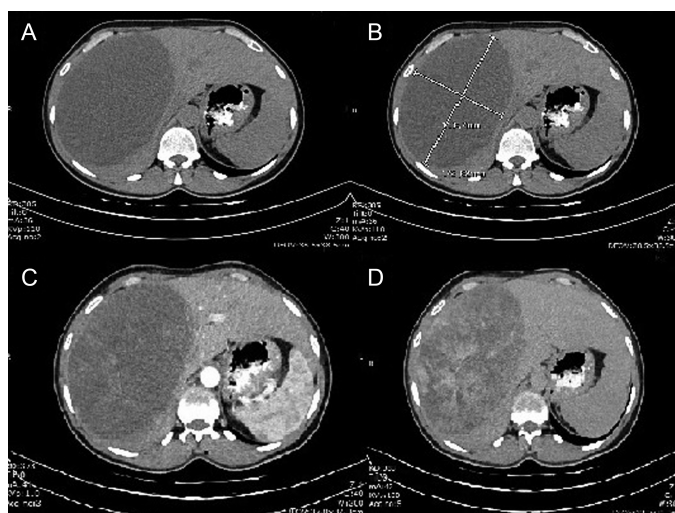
A-D. CT showed a large, regular, hypodense 17 × 12 cm mass in the right lobe of the liver (A–B: precontrast CT image). Blood vessels were observed in the tumor in the arterial phase (C: arterial phase), and the tumor was progressively unevenly enhanced in the delayed phase (D: delayed phase). CT, computed tomography.
